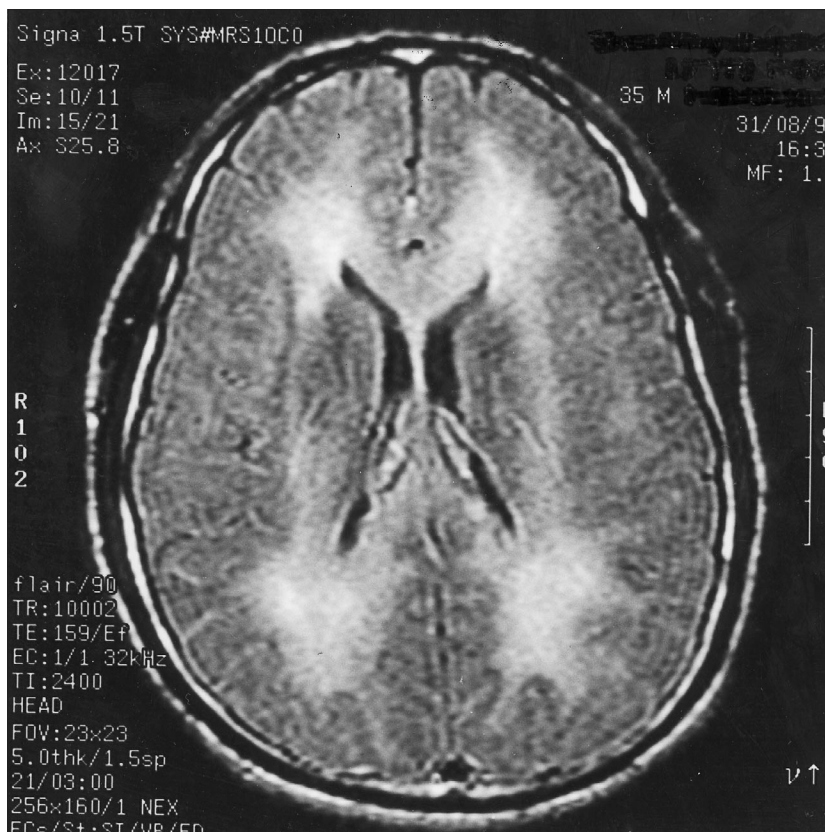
A fluid attenuation inversion recovery (FLAIR) magnetic resonance image of the brain showing diffuse, symmetrical periventricular hyperintensities.
